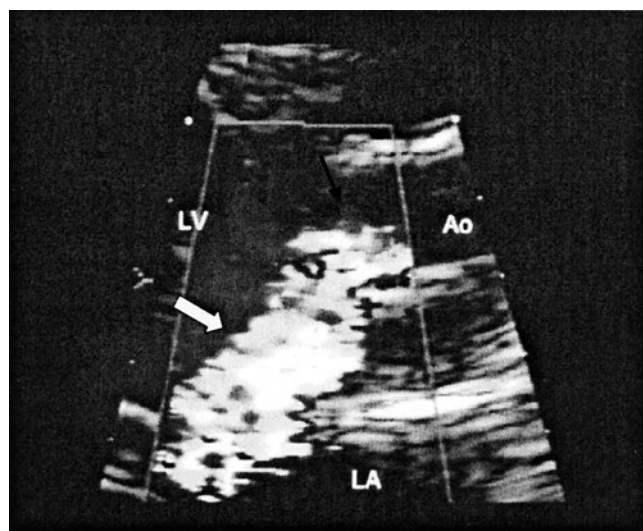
Parasternal view of aortic regurgitation (AR) using color-flow imaging. The flow convergence (*thin arrow*) and jet (*thick arrow*) are well seen. Note the limited expansion of the jet owing to its eccentricity.
